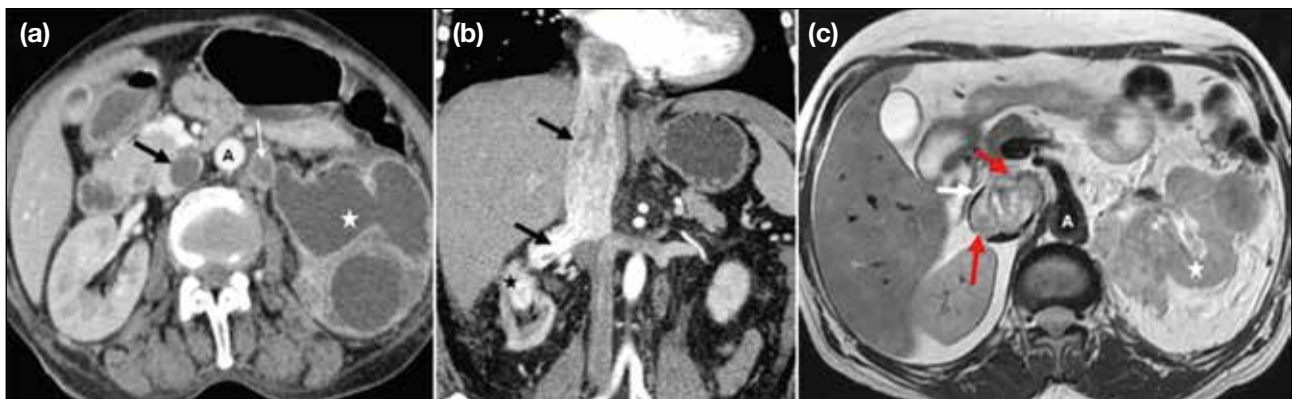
Renal cell carcinoma (RCC) involving the inferior vena cava (IVC) in three patients. (a) Patient 1. Axial contrast-enhanced computed tomography (CECT) image shows left RCC (star) with an enhancing tumour thrombus in the dilated left renal vein (white arrow) and a bland thrombus in the IVC (black arrow). (b) Patient 2. Coronal CECT image shows intense heterogeneous enhancement of right upper-pole RCC (star), with an enhancing tumour thrombus in the right renal vein and IVC (black arrows), extending up to the right atrium. (c) Patient 3. Axial T2-weighted magnetic resonance image shows left RCC (star) with tumour thrombus in the IVC (white arrow) focally invading the IVC wall (red arrows).
